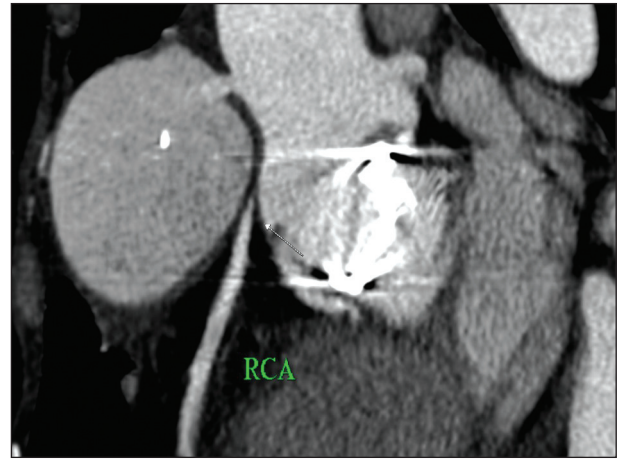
A 64-slice CT with contrast enhancement (CECT) shows the diameter of neck of aneurysm is 1 cm, significantly compressing the origin and proximal part of right coronary artery (RCA). The distance between RCA and neck of pseudoaneurysm is 5 mm suggesting a possible contraindication to percutaneous closure of pseudoaneurysm
